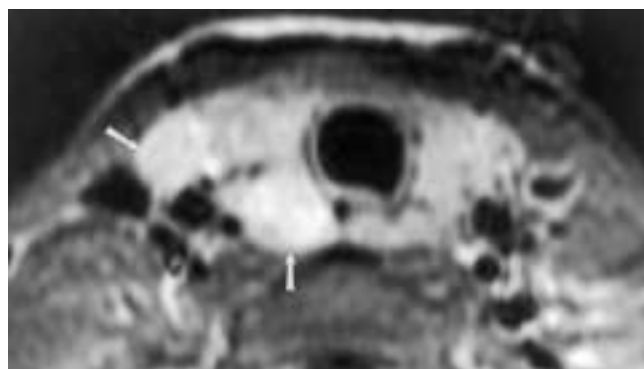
Hashimoto's thyroiditis. Enhanced axial T1-weighted MR image shows two nodules (arrows) in the right lobe of the thyroid gland that enhance more than the remainder of the gland.
